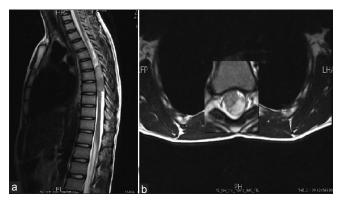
(a) Sagittal section T-2 MRI showing lesion at T5-T7 levels resulting in significant cord compression. (b) Axial section T-2 MRI (with magnification tool of PACS) showing an intradural extra-medullary mass compressing the spinal cord
